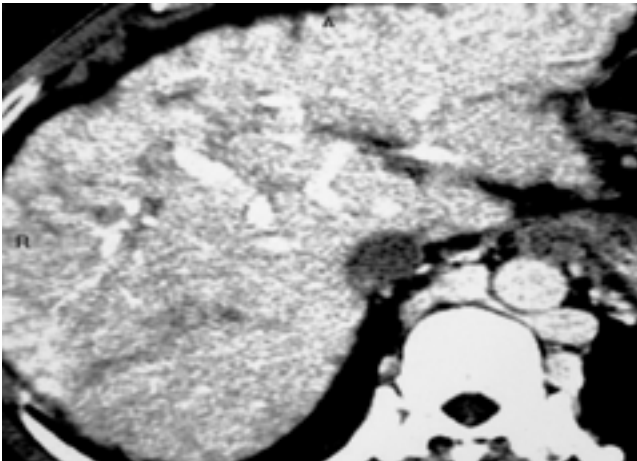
Abdominal CT shows engorged azygos and hemiazygos veins. Hepatic IVC is filled with thrombus.
